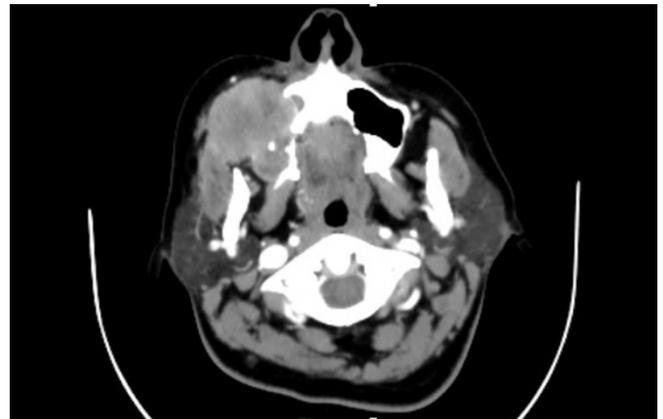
Contrast CT Scan depicting the aggressive changes and extension of the lesion to pterygoid plates.
